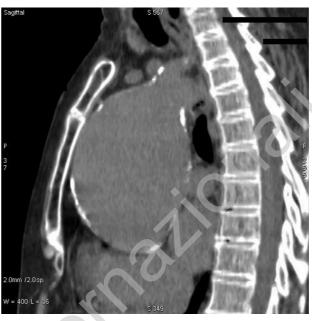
Computed tomography scan (sagittal view). Close relationship between the aneurysm and the sternum.
